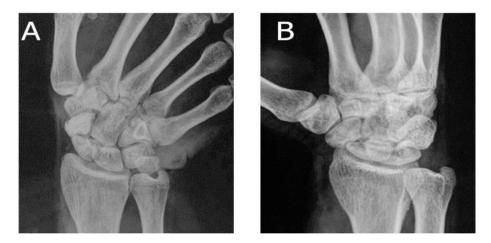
Showing scaphoid waist nonunion fracture in antro-poosterior (B) and scaphoid (A) radiography views.
